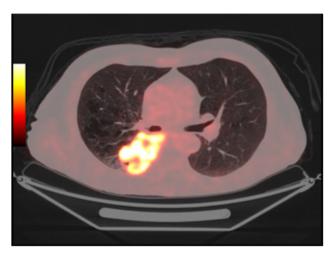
The mass image in the right lung *(horizontal cross-section view of thoracic CT scan).*
